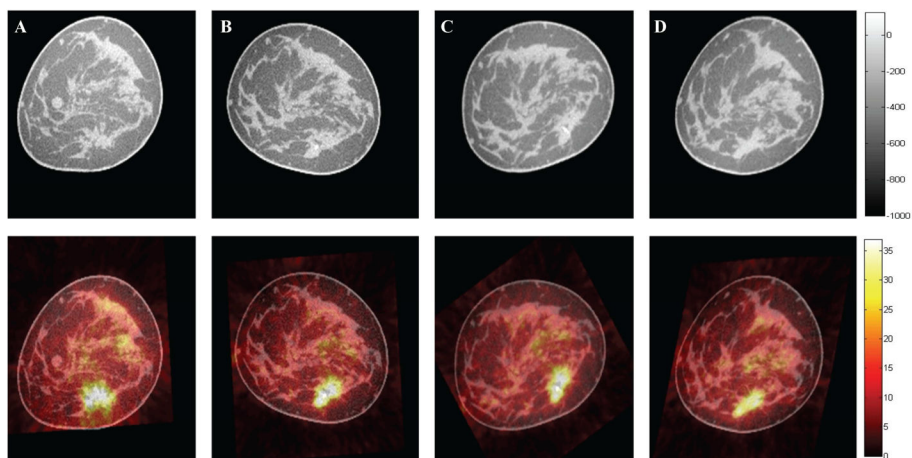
Monitoring of early response to NAC in breast cancer using dedicated breast PET/CT in a representative case; Top row: Representative CT sections. Bottom row: Corresponding fused PET/CT sections showing the lesion (hot spot); (A) scan at baseline (column 1), (B) scan after one therapy cycle (column 2), (C) follow-up scan registered to the baseline scan using affine registration (column 3), (D) follow-up scan registered to baseline scan using the DD method (column 4). The colorbars for PET are on a relative scale. This patient was found to be a partial responder based on pathology, consistent with these images.
